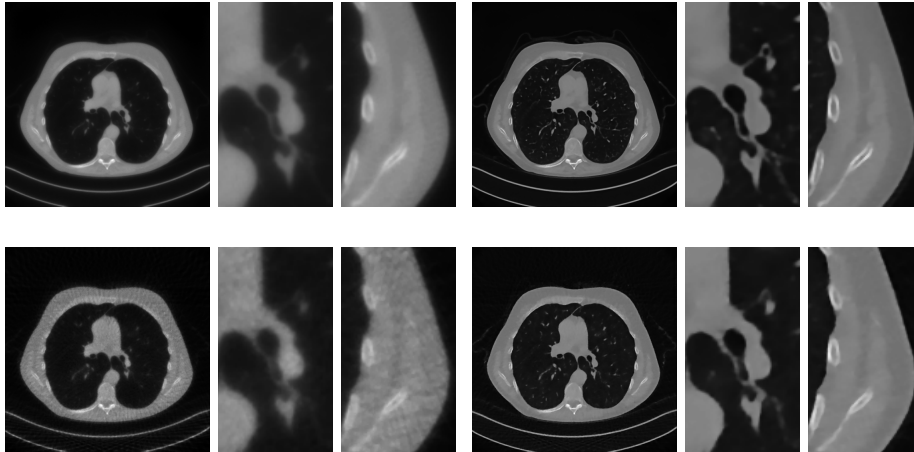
Results on a test image from the Mayo data set, under the $P_{360,360}$ (upper row) and the $P_{180,60}$ (bottom row) CT protocol. Left: x_{RIS} ; right: x_{RISING} .
